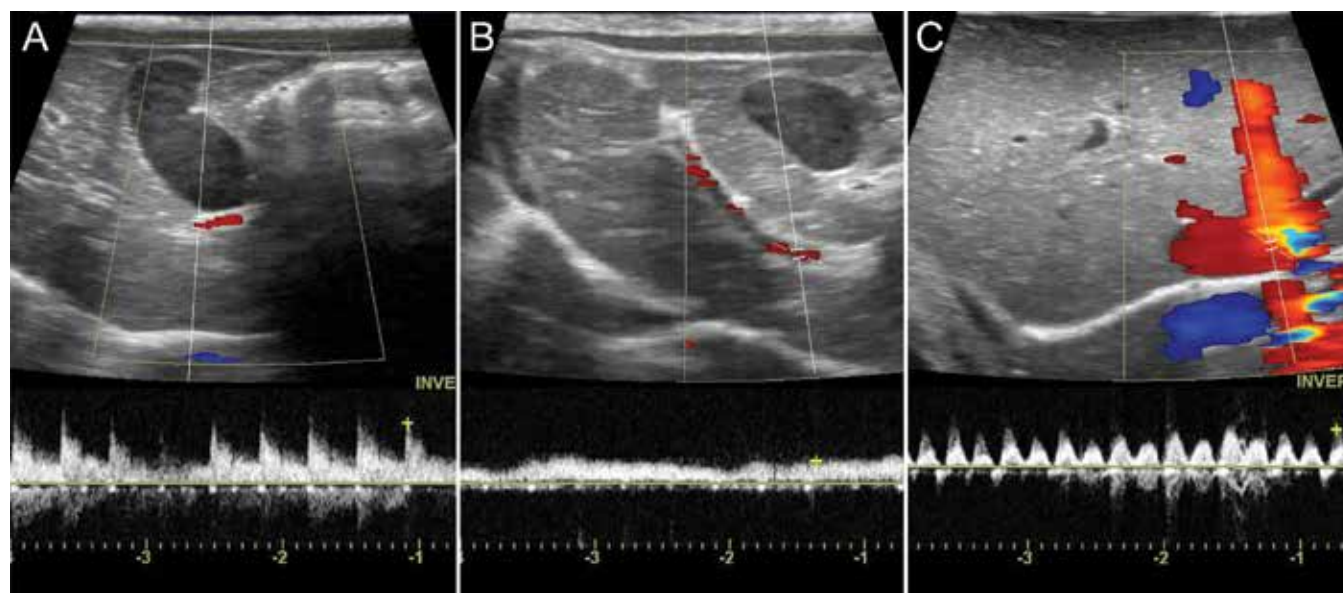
Vascular structures of the liver measured during ultrasonographic examination.
